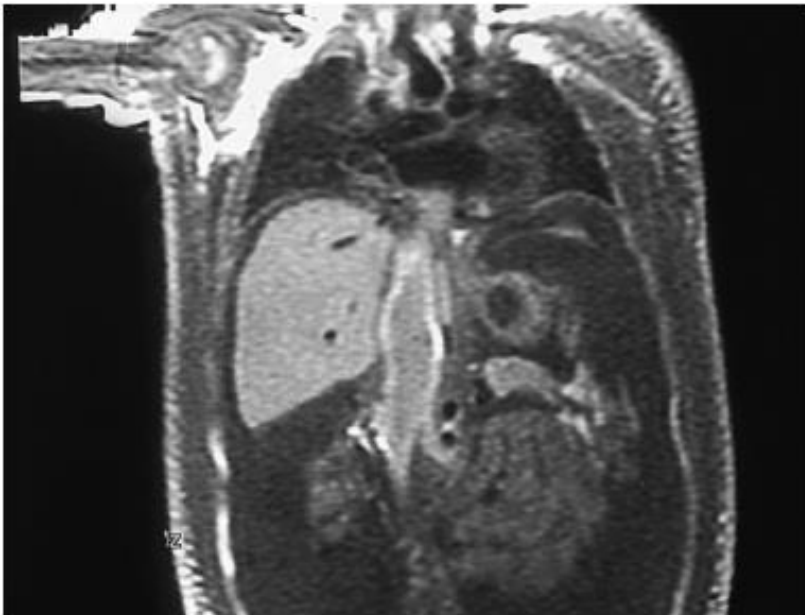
MRI depicting extension of Wilms tumor into the inferior vena cava.
